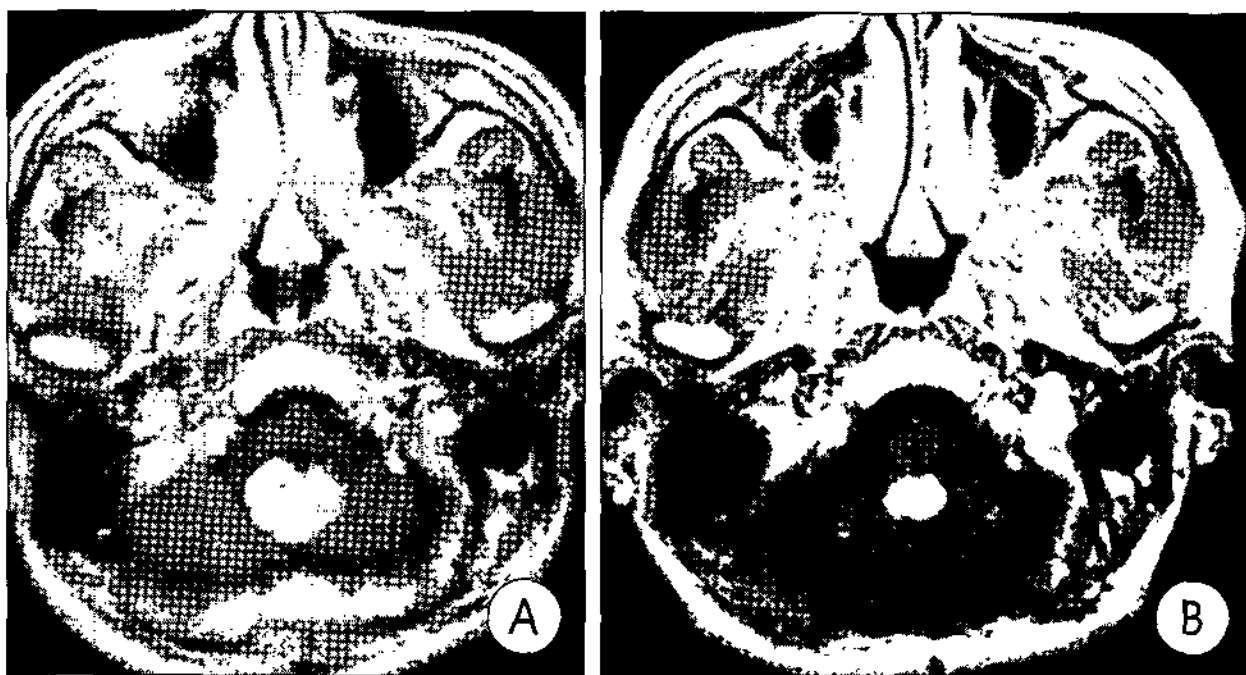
Case 2 : Axial gadolinium enhanced T1 weighted magnetic resonance (MR) images. Preoperative MR images(A) showing multiple tumors in the cerebellar hemisphere and inferior vermis. Postoperative MR image(B) two years after radiosurgery showing that one is shrunken and another two unchanged.
